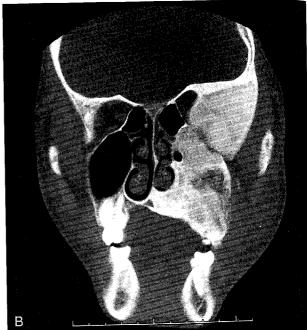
Six months between the second resection and the removal of the pituitary adenoma. (A, B) Computed tomographic scans demonstrate further recurrence and expansion of the remaining rib grafts by fibrous dysplasia (arrow).
